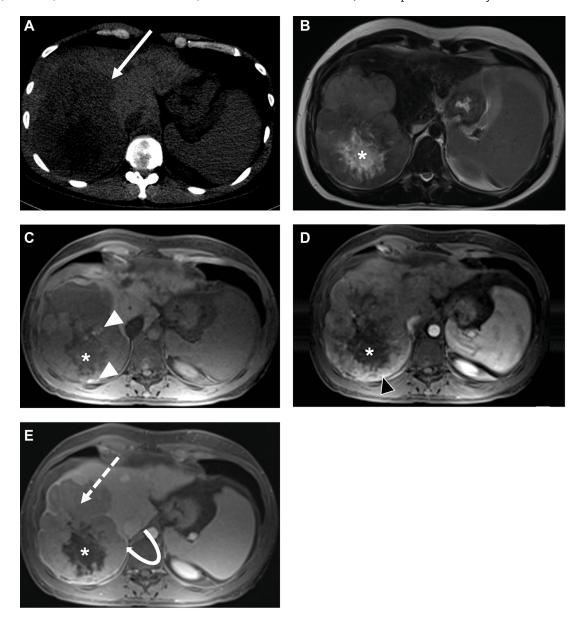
(A) Noncontrast computed tomography showed signs of chronic liver disease, splenomegaly, and a 14-cm hypoattenuating mass in the right hepatic lobe (arrow). (B-E) Magnetic resonance imaging demonstrated the heterogeneous mass with central necrosis (asterisks), moderate high signal intensity (SI) on T2-weighted image (WI) (B), low SI on T1WI with areas of high SI suggestive of internal hemorrhage (C, white arrowheads), areas of arterial hyperenhancement (D, black arrowheads), washout appearance (dashed arrows) and capsule (curved arrow) on delayed phase (E).
